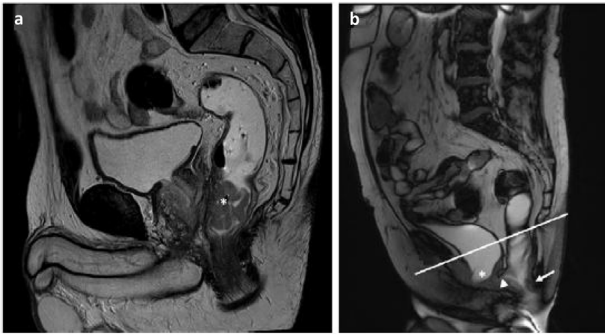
Pelvic MRI images with T2-weighted sequences in the sagittal plane after rectal administration of ultrasound gel (biphasic contrast). a) Cancer of the lower rectum (*asterisk*). b) Weakness of the pelvic floor with cystocele (*asterisk*), peritoneocele (*arrowhead*) and rectocele (*arrow*). PCL: pubococcygeal line.
